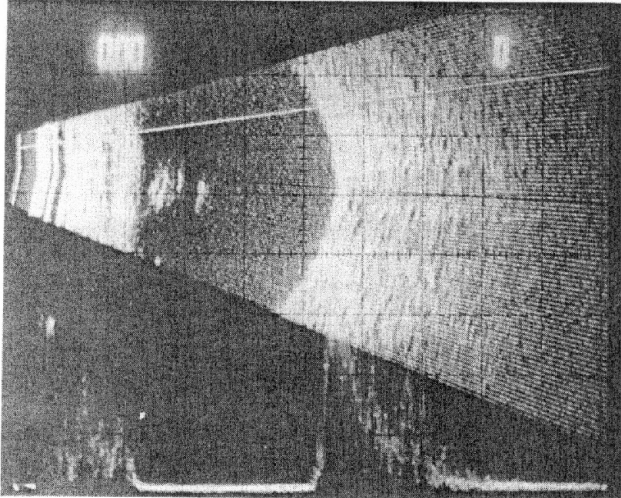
(Awan): Left eye. A few weeks after the intraocular lens implantation, the B-scan ultrasonography shows healthy eye with no elevation of the retina or the choroid.
